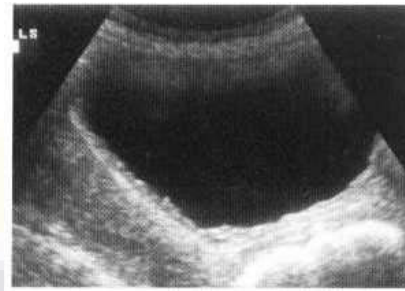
Longitudinal ultrasound of the bladder showing wall thickening and trabeculation (replacement of normal smooth inner aspect by regularly undulating appearance).
